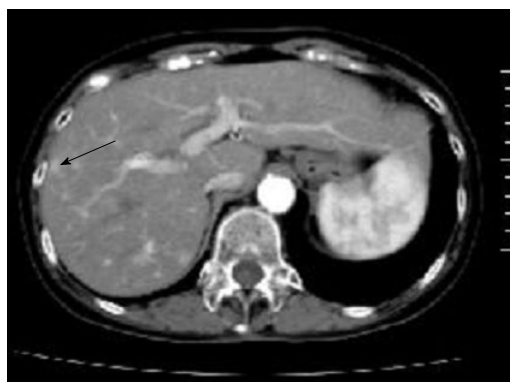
Contrast-enhanced abdominal computed tomography. A well-circumscribed nodule showing early arterial enhancement in S8 (arrow).
